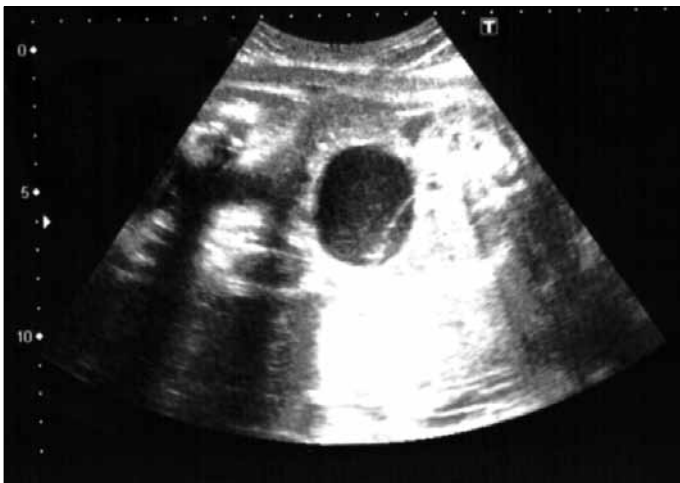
The ultrasound finding of ovarian cyst with a diameter of 41x33 mm at 33 weeks gestation
